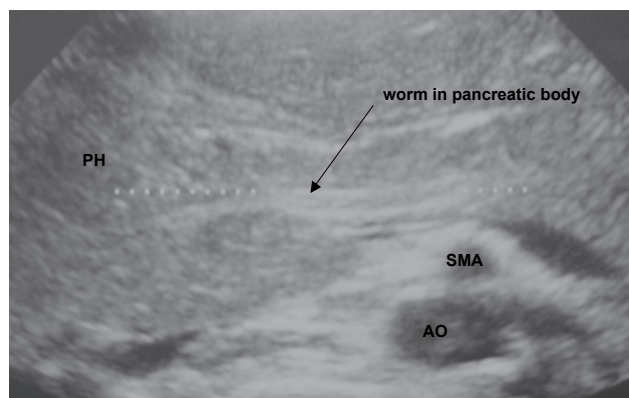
Transverse ultrasound scan through epigastrium demonstrating pancreatic head and body with two parallel echogenic lines consistent with a worm in the pancreatic duct (PH = pancreatic head; SMA = superior mesenteric artery; AO = aorta).
